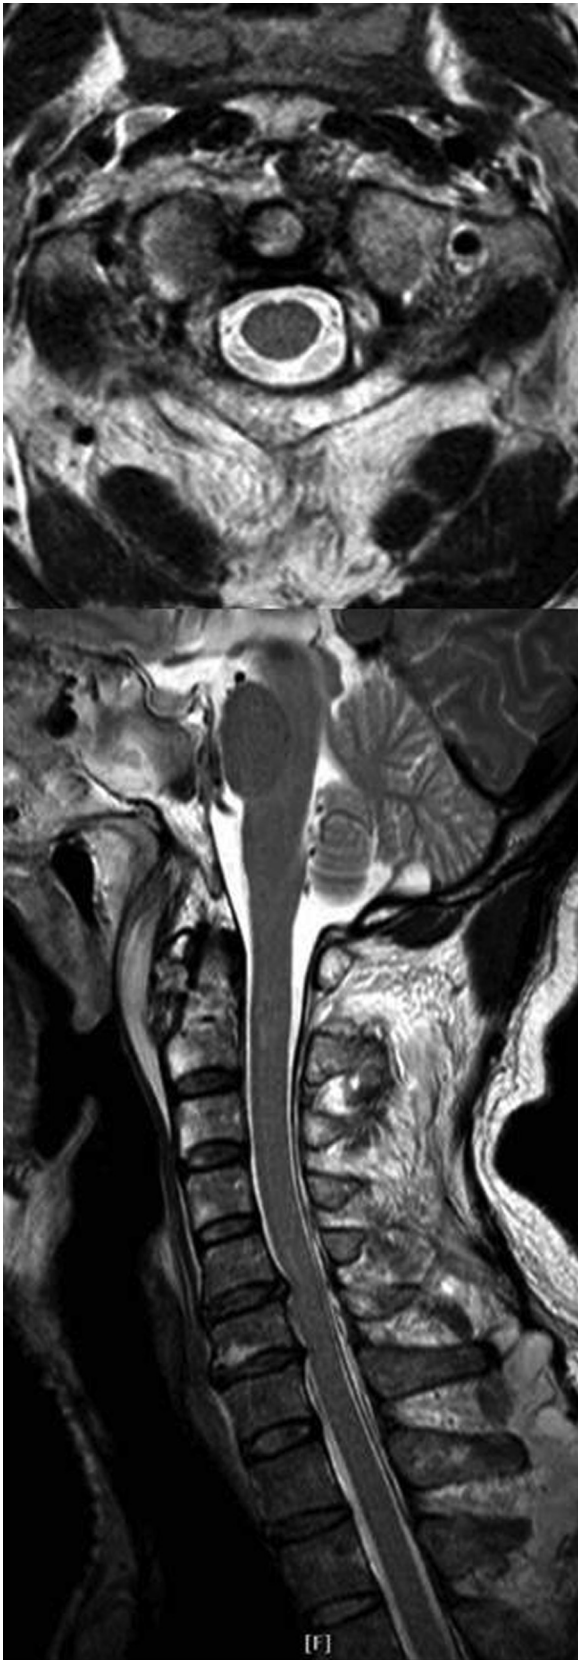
A T2-weighted axial magnetic resonance image of the cervical spine showing no significant transverse ligament rupture, and a T2-weighted sagittal magnetic resonance image of the cervical spine showing a preoperative high-signal change of the spinal cord at the C2 level.
